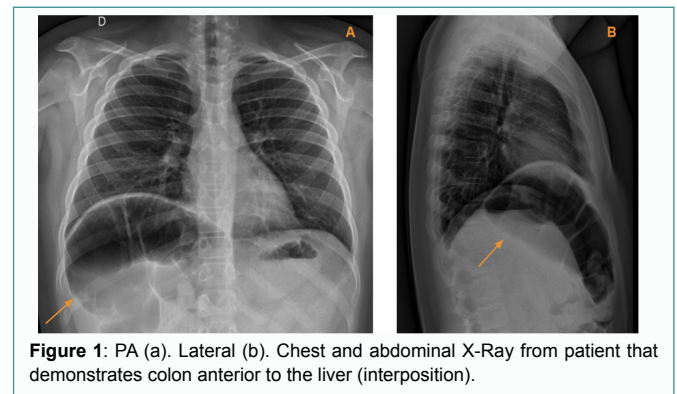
PA (a). Lateral (b). Chest and abdominal X-Ray from patient that demonstrates colon anterior to the liver (interposition).
